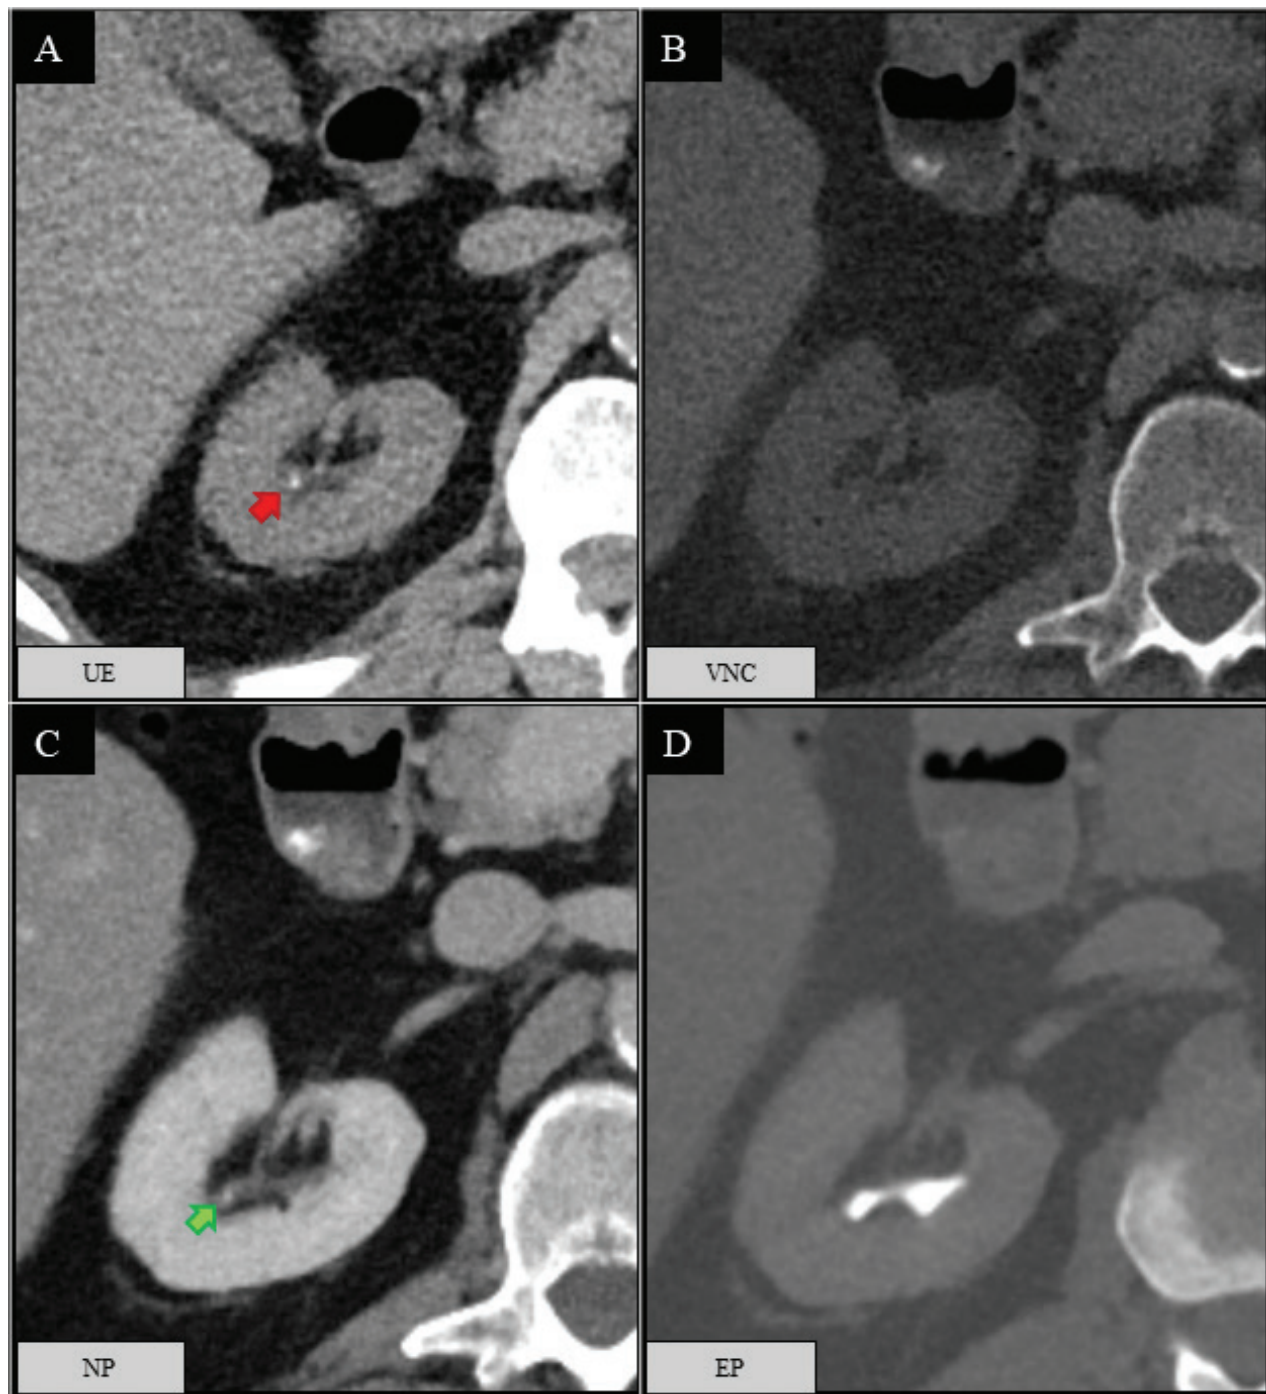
(A–D) A 60-year-old male with a stone (red arrow) in the right kidney. The experimental CT was scored negative for kidney stone by both readers. However, the stone (green arrow) was retrospectively visible on axial NP (C). The patient required no active stone treatment during the follow-up time. CT: computed tomography; NP: nephrographic phase; UE: unenhanced; VNC: virtual non-contrast; EP: excretory phase.
